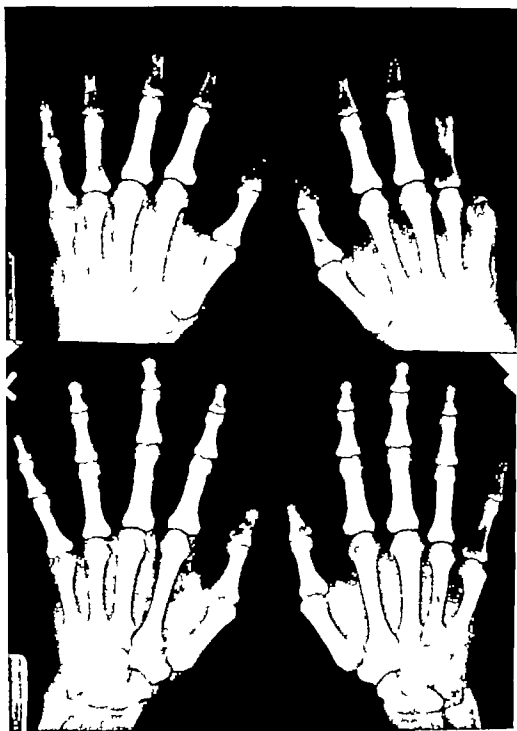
Radiographs of hands of a patient with a functioning parathyroid adenoma. The cystic changes and the cortical alterations seen in the upper radiographs have dramatically changed in the lower radiographs which were taken 9 months after the removal of the parathyroid adenoma. (W U negs. 57-6267 and 57-6268.)
